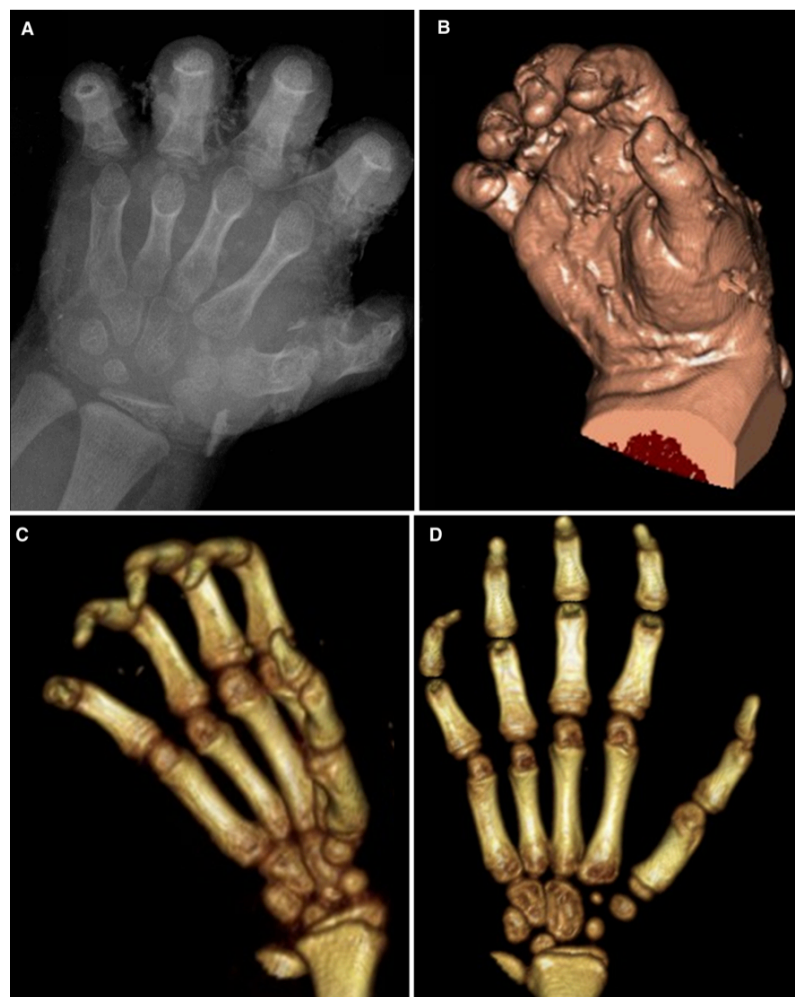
Maturation of hand and wrist. A) Radiograph B) Virtual representation of hand from CT C) 3D reconstruction of the hand that can be view in any plane D) Manipulation of 3D reconstruction to open out hand.
